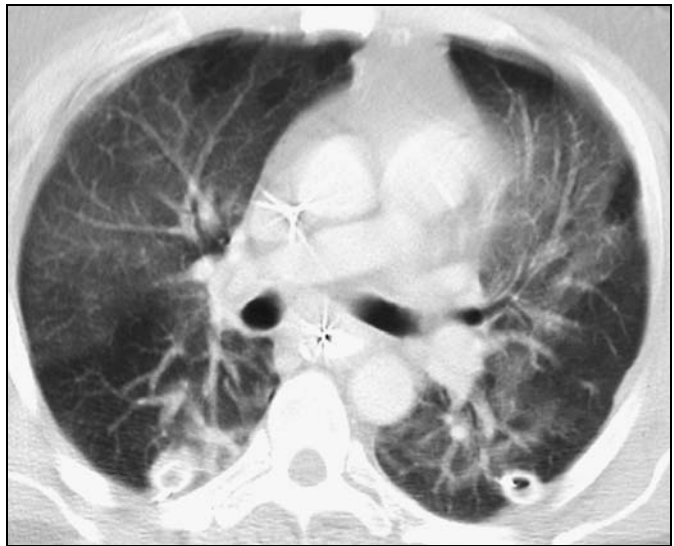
75-year-old woman being treated for promyelocytic leukemia and presenting with all-transretinoic acid syndrome of noncardiogenic edema. Thick-section CT image through carina shows widespread ground-glass opacities and small bilateral pleural effusions.
